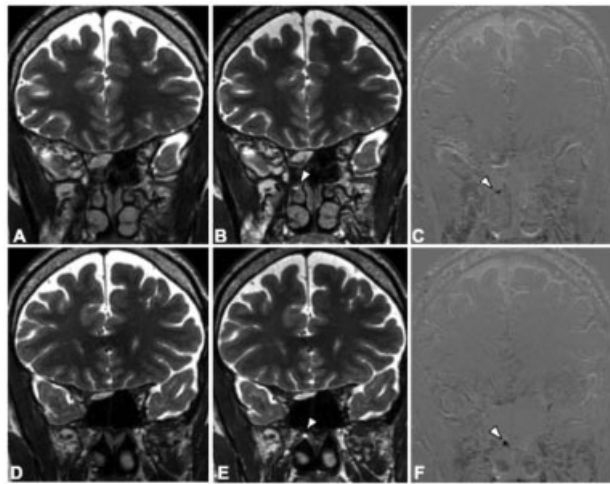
MRI of a patient with a low-flow CSF leak from a cribriform meningoencephalocele. No pooling CSF is observed in the early acquisitions (A and D), however, CSF volume (denoted by white arrow heads) is seen on the late acquisition (B and E). Image subtraction (C and F) between the early and late acquisitions shows signal hypointensities, representing accumulated CSF (denoted by white arrow heads).
